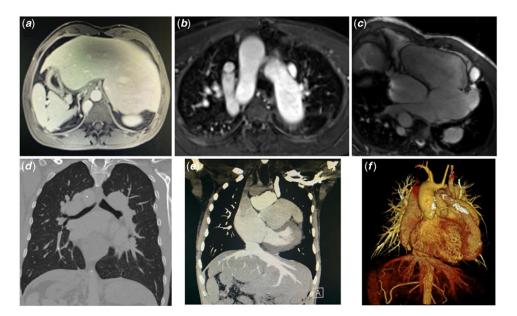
(*a*) Cardiac magnetic resonance (CMR) image revealing an abdominal situs inversus, with the liver medial; (*b*) CMR image of the great vessels: the aorta was anterior and to the right of the pulmonary artery, with an right-sided aortic arch; (*c*) CMR image revealing the venous drainage of four pulmonary veins to the left-sided atrium, which was connected to the morphological systemic right ventricle; (*d*) CT image showing bilobated lungs and hyparterial main bronchi; (*e*) CT image confirming the similar morphology of the atrial appendages (chicken wing); (*f*) CT multiplanar reconstruction: the aorta was anterior and to the right of the pulmonary artery; persistence of the left superior vena cava and an interrupted inferior vena cava continued via the azigos vein to the right superior vena cava; ventriculoarterial discordance and hypoplastic main pulmonary artery were also observed; a calcified left ventricle to the pulmonary artery conduct was observed.
